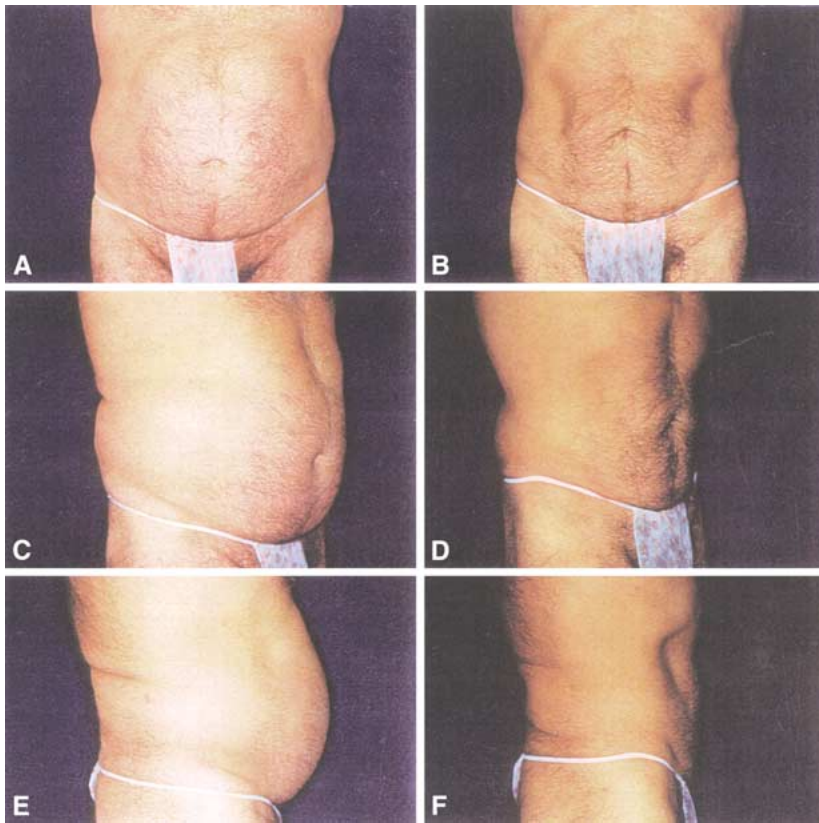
A 56-year-old man who underwent UAL of the abdomen and flanks. Ultrasonic energy was used for a total of 75 min, including 45 min spent on the abdomen alone. Total aspirate was approximately 1900 cc. (A, C, E) Preoperative views. (B, D, F) Postoperative views at five months.
